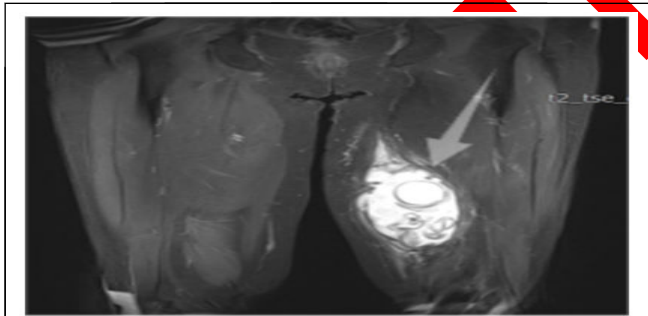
MRI T2 sequence in the horizontal plane of the thighs.
